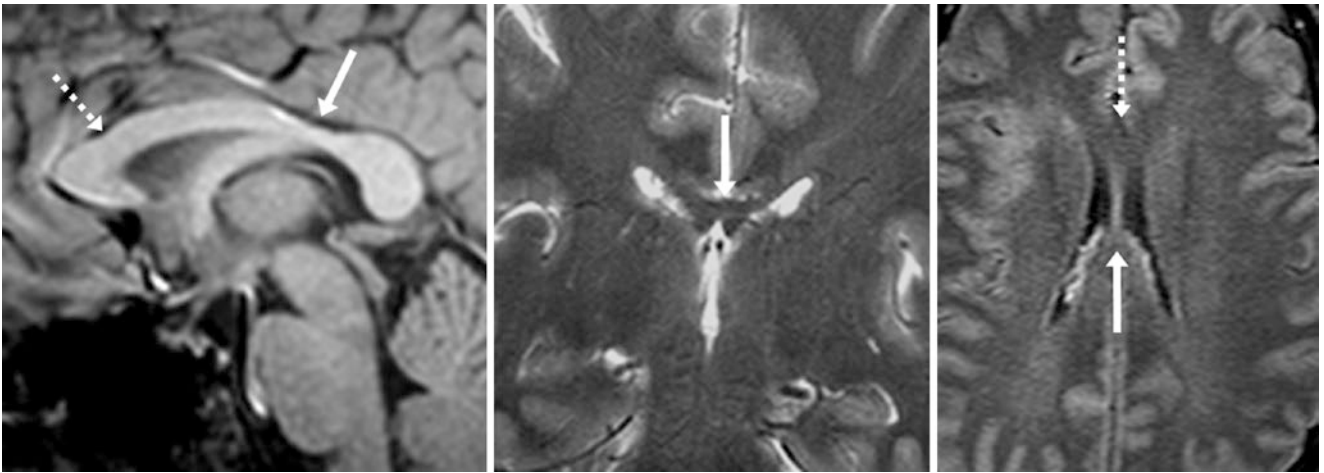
A 44 year old with an otherwise negative MRI obtained for nonspecific symptoms that demonstrated a normal isthmus on a midline sagittal T1WI (*arrow, left*). Coronal T2WI through the isthmus (*middle*) and an axial FLAIR image (*right*) show the disparate thickness of the isthmus (*arrows*) relative to the anterior body (*dashed arrows*)
